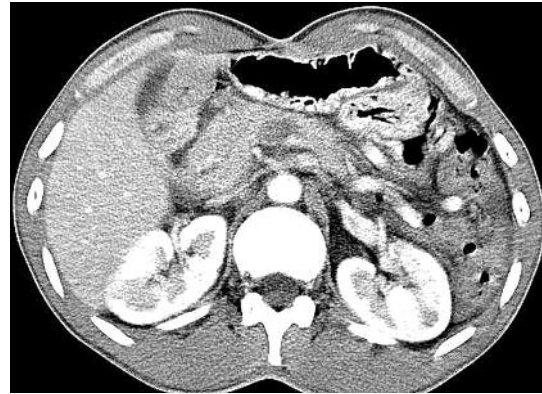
Computed tomography revealing solid tumour within the body of the pancreas
